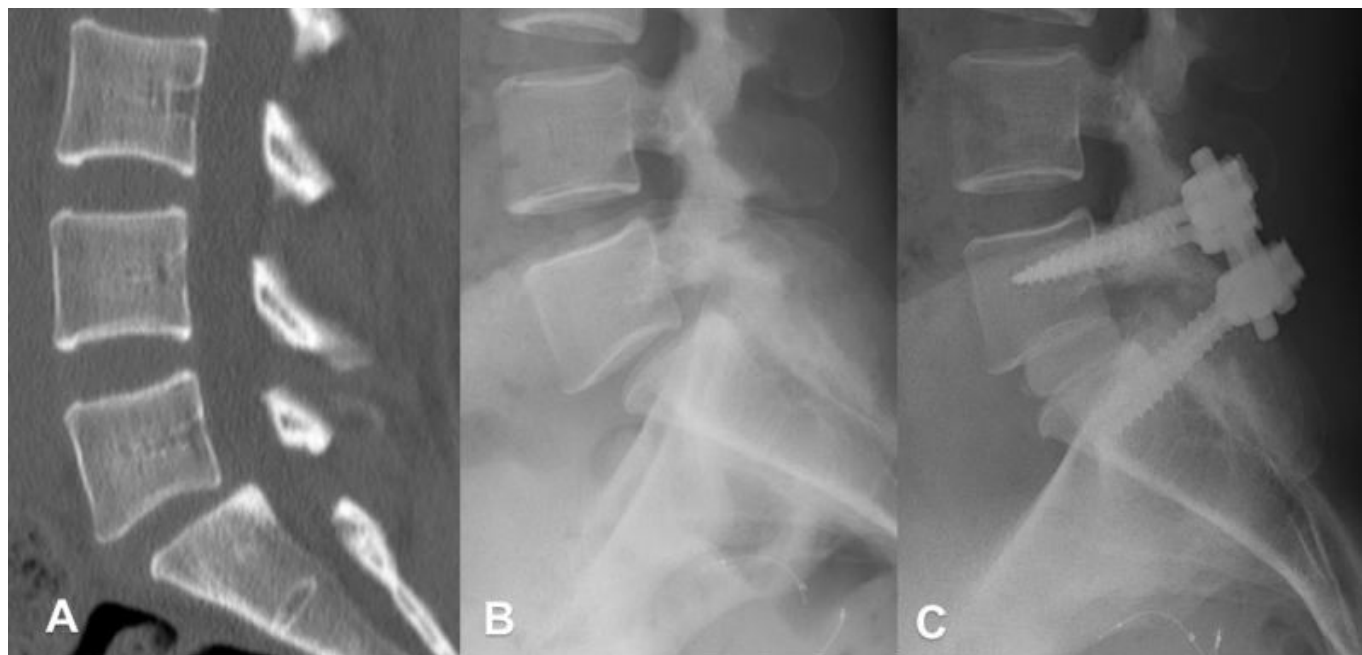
(A, B, C) 52 year old male with a degenerative spondylolisthesis at L5 – S1. (A) CT sagittal view of a low grade slip. (B) Lateral radiograph pre-operative intervention. (C) Surgically treated with L5 – S1 decompression, instrumented fusion and placement of an interbody graft between L5 and S1.
